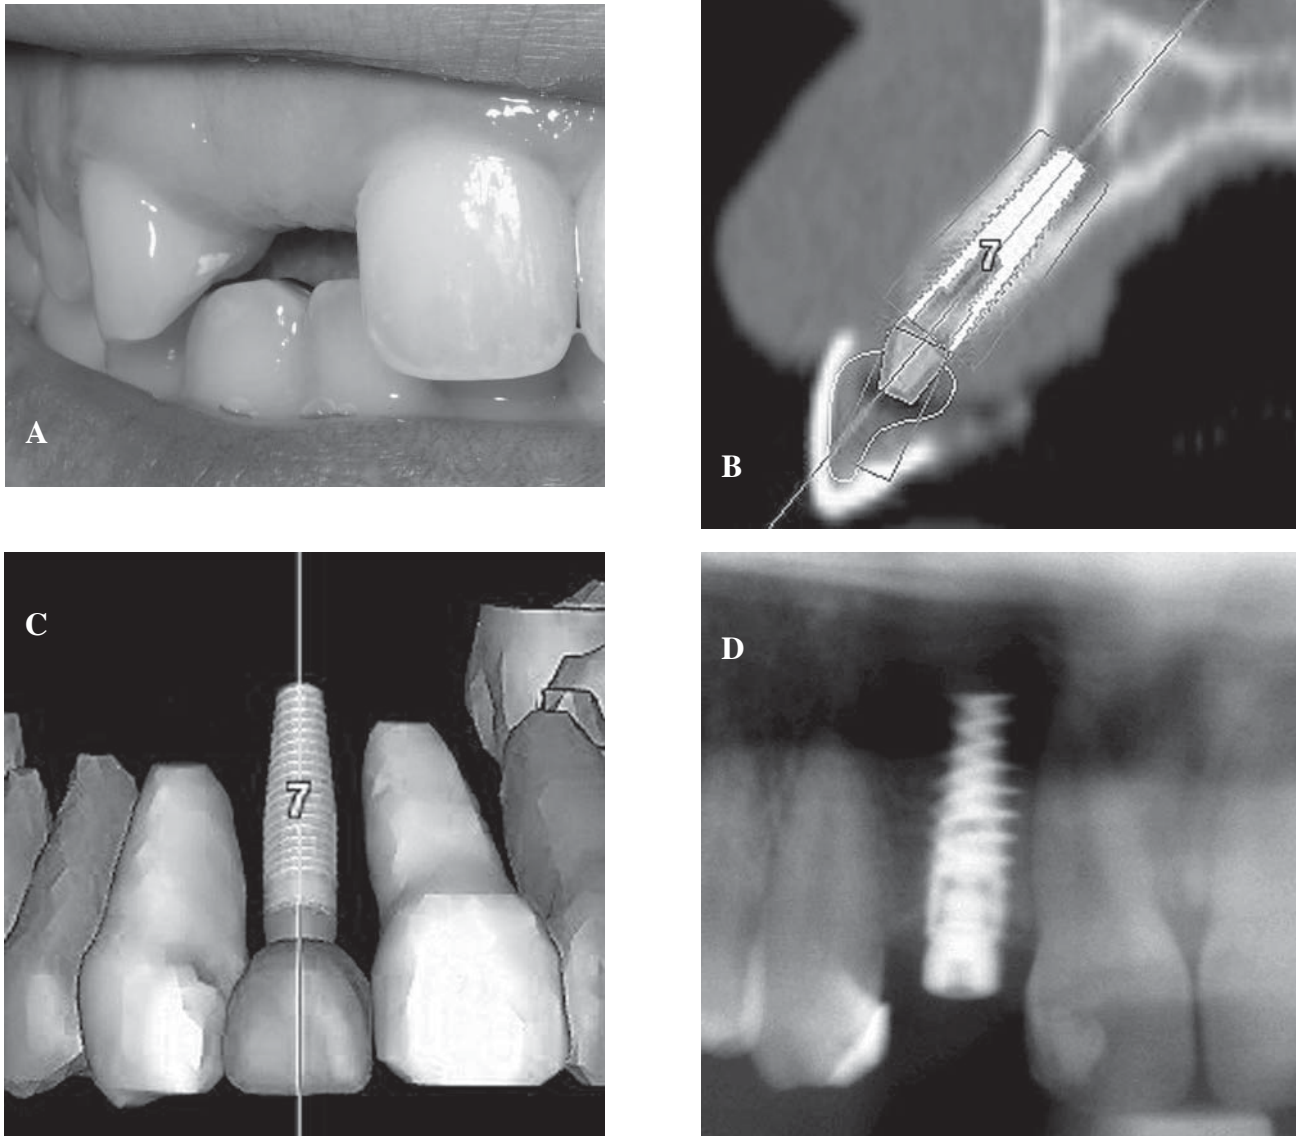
A 17-year-old female with a congenitally missing tooth #7. A. Preoperative photograph, B. Cross-sectional view (Simplant®.) Note placement of “virtual” angled abutment, C. Segmentation has been performed, removing the bone surrounding the adjacent teeth. An implant can then be accurately placed virtually, between the roots of the adjacent teeth, D. Postoperative radiograph with implant in place.
